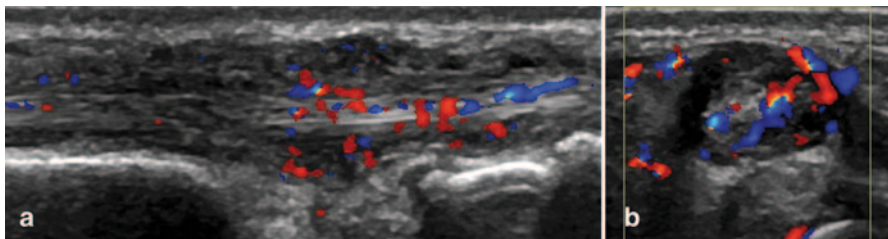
Longitudinal (a) and transversal (b) view over the extensor carpi ulnaris tendon showing B-mode and Doppler tenosynovitis
